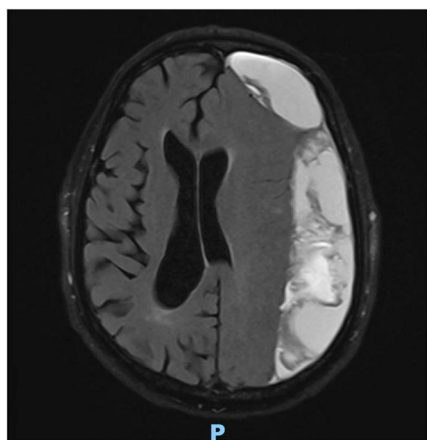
FLAIR MRI study, axial plane.
